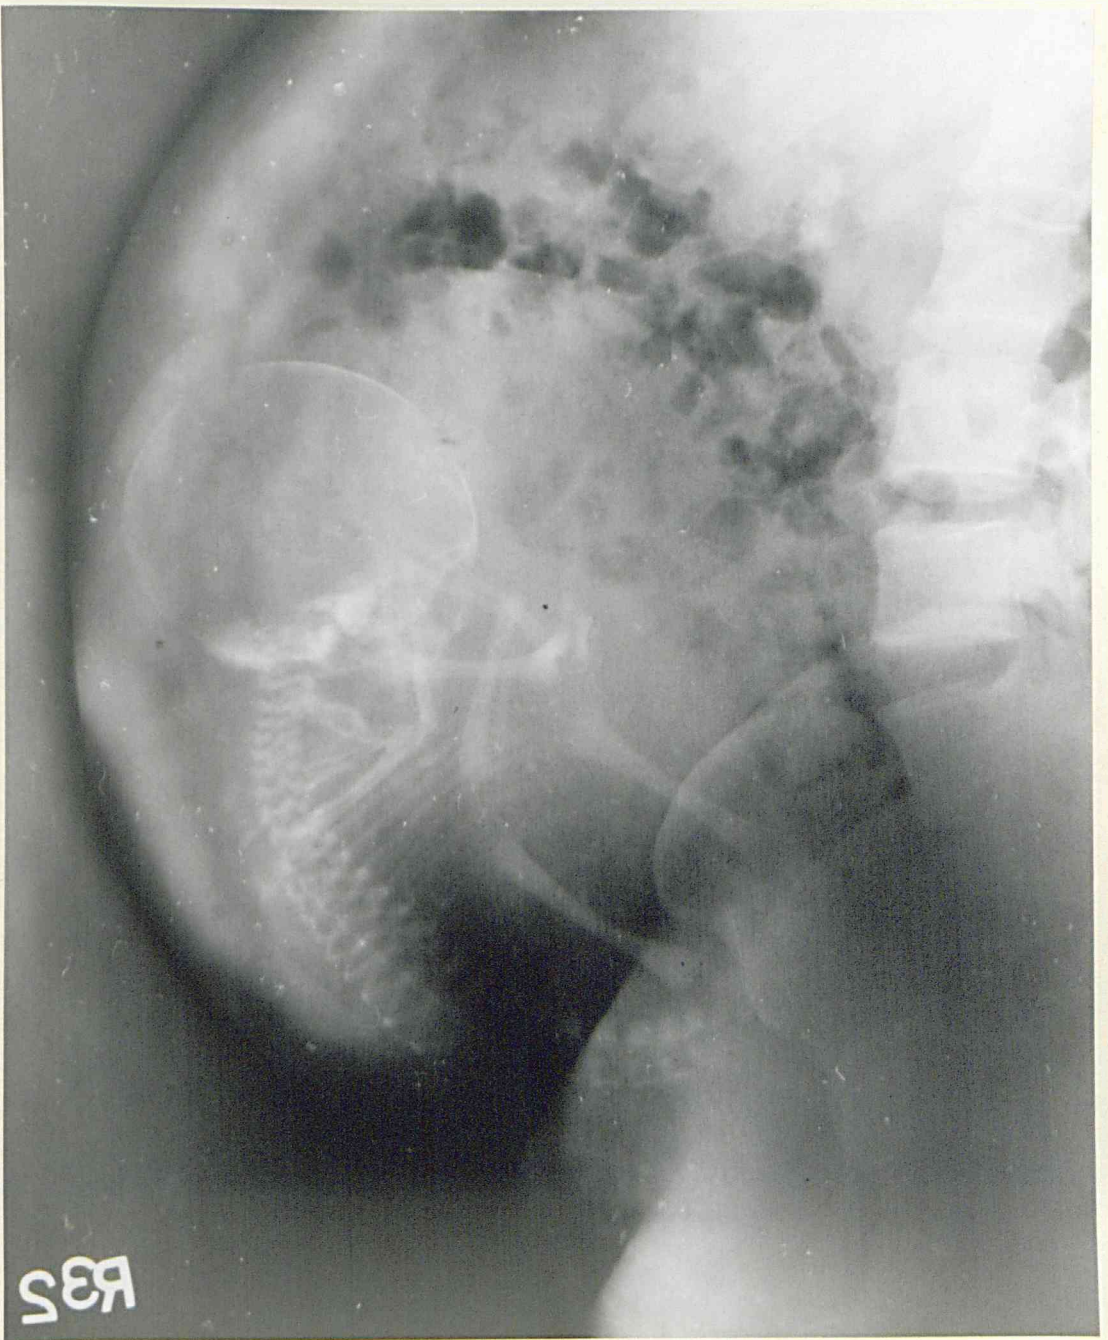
Lateral radiograph of the abdomen in a breech presentation. The unilateral thickening corresponding to the placenta is on the posterior wall of the upper uterine segment. (Case No. 90).
